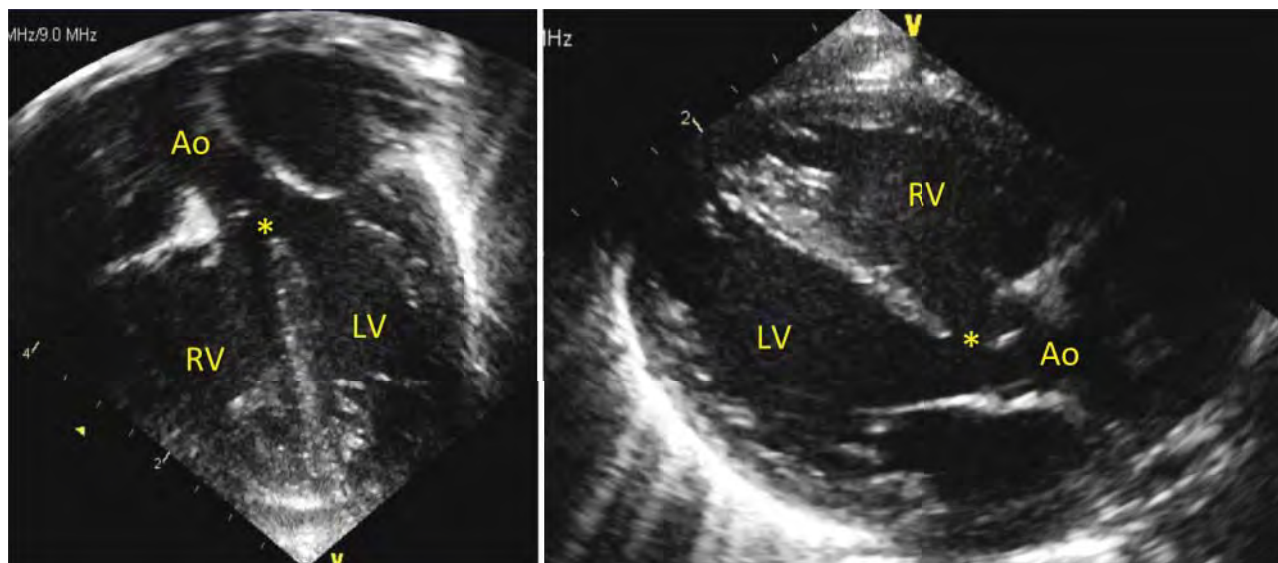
Ventricular septal defect (*) and overriding of aorta (Ao) can be seen on apical (left panel) and parasternal long-axis views (right panel). LV, left ventricle; RV, right ventricle.
